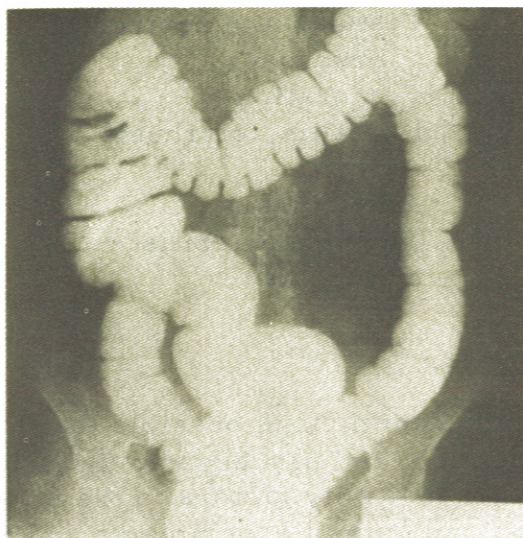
Roentgenogram of normal colon.
